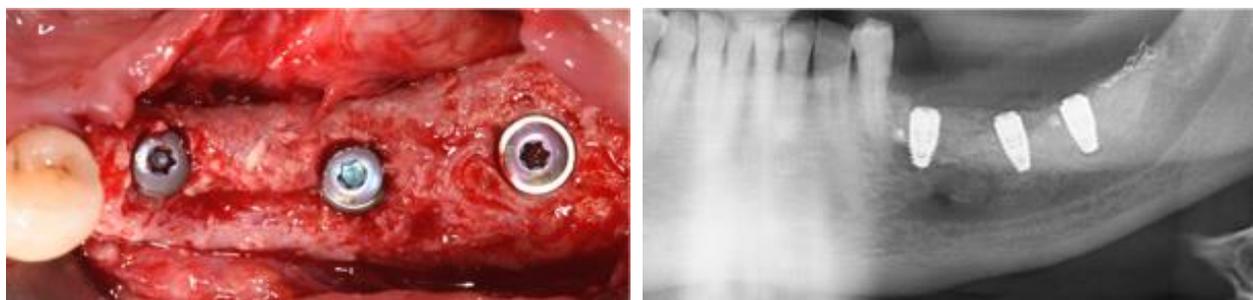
Clinical images and panoramic radiograph after implants placement
